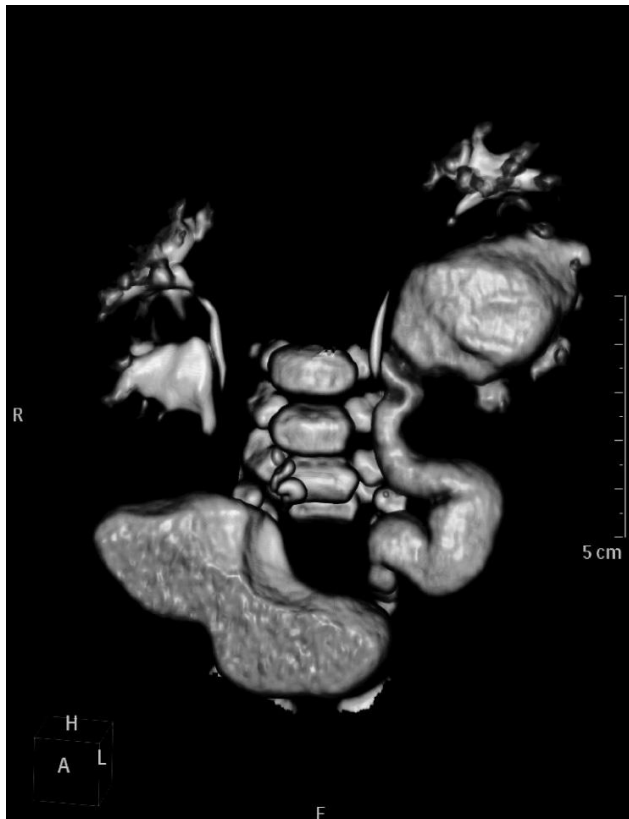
Lower dose computed tomography urography. Double kidneys, bilateral hydronephrosis of the lower part of the collecting systems associated with high grade of vesicoureteral refluxes, narrow cortex of the left kidney.
